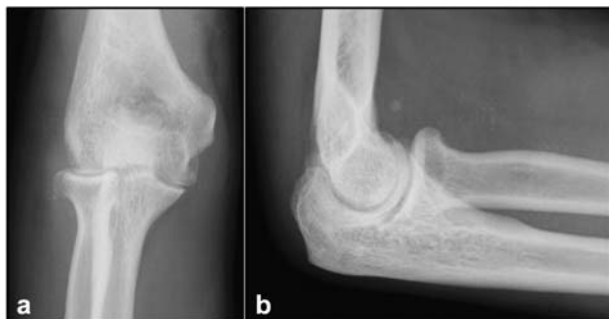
Initial radiographs of the elbow: anteroposterior (a) and lateral (b) views.
